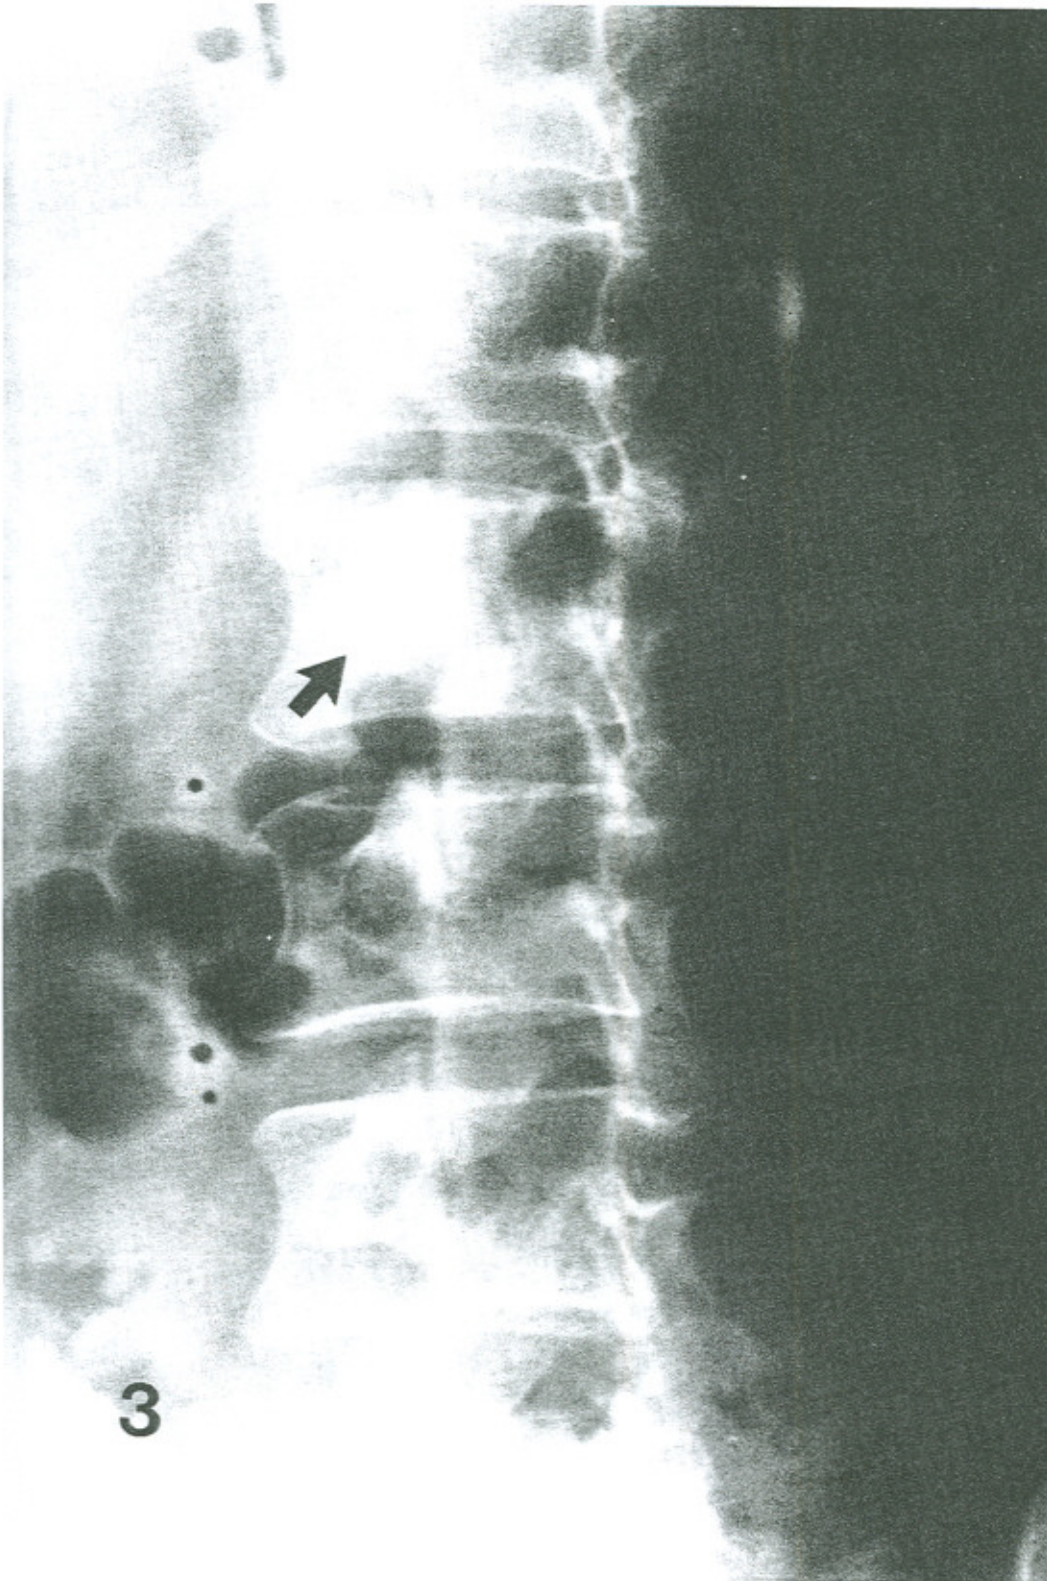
Oblique radiograph of the lumbar spine demonstrating increased density of the right pedicle of L2 and altered cortical margins.
